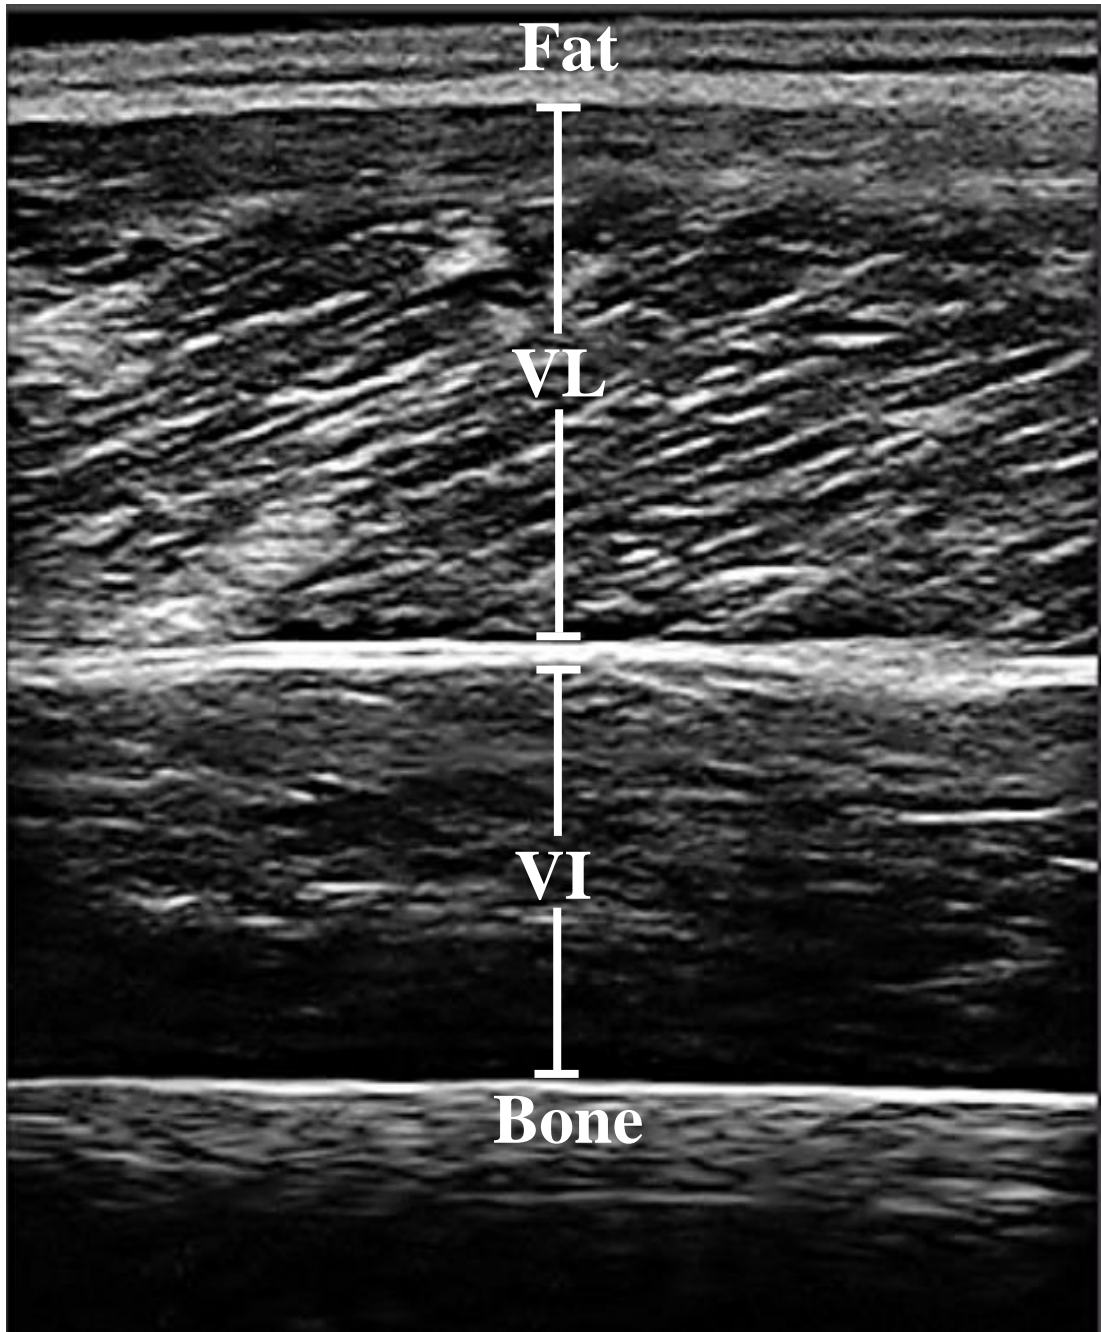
Typical ultrasound sagittal image of the left lateral quadriceps. Features from top to bottom of the image are: fat layer, aponeurosis, vastus lateralis, aponeurosis, vastus intermedialis and femur.
